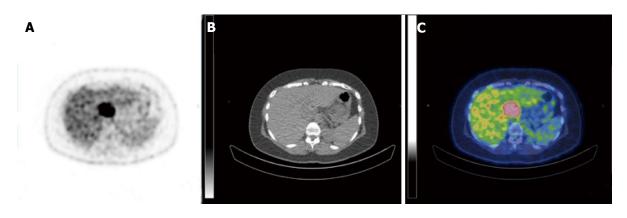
Positron emission tomography computed tomography using 18-fluoro-deoxyglucose showing the 18-fluoro-deoxyglucose avidity of the segment 1 tumor. A: PET; B: CT; C: PET-CT fusion. PET: Positron emission tomography; ¹⁸FDG: 18-fluoro-deoxyglucose; CT: Computed tomography.
